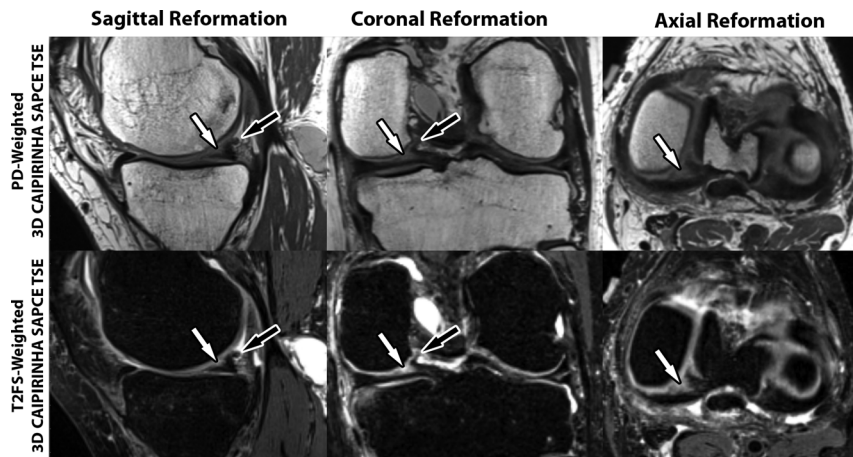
A 62-year-old man with chronic knee pain. Four-fold–accelerated 10-minute 3.0-T 3D isotropic knee MRI using proton density–weighted and fat-suppressed T2-weighted 3D CAIPIRINHA SPACE TSE pulse sequences. Sagittal, coronal, and axial MR reformation images demonstrate a degenerated, partial-thickness medial meniscus tear (white arrows) of the posterior segment with a small displaced fragment (black arrows). The MRI scans were obtained with a commercial 3.0-T MRI system (slew rate, 200 T/m/s; gradient strength, 45 mT/m) and a dedicated 1-transmit 15 receiver channels knee coil.
